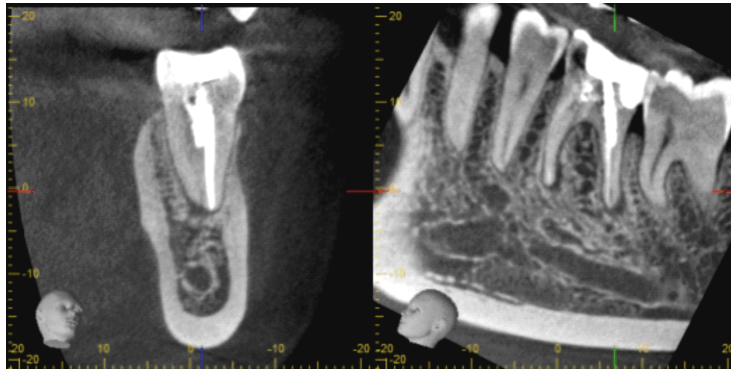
Preoperative transverse, respectively longitudinal CBCT image showing the distal root of tooth 36 with previous filling of distobuccal canal. A metallic screw post is cemented in distolingual uninstrumented root canal. CBCT: Cone-beam computed tomography.
